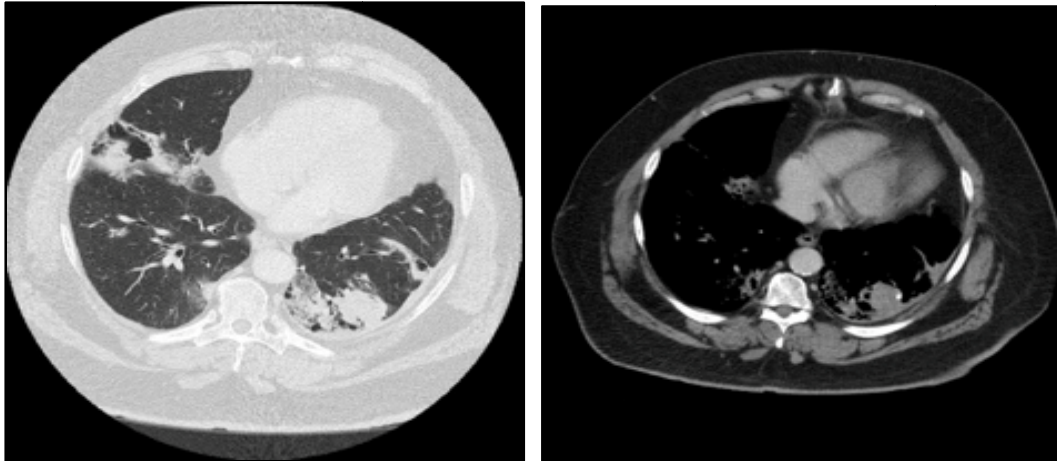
Initial chest CT revealing peripheral-predominant areas of consolidation
